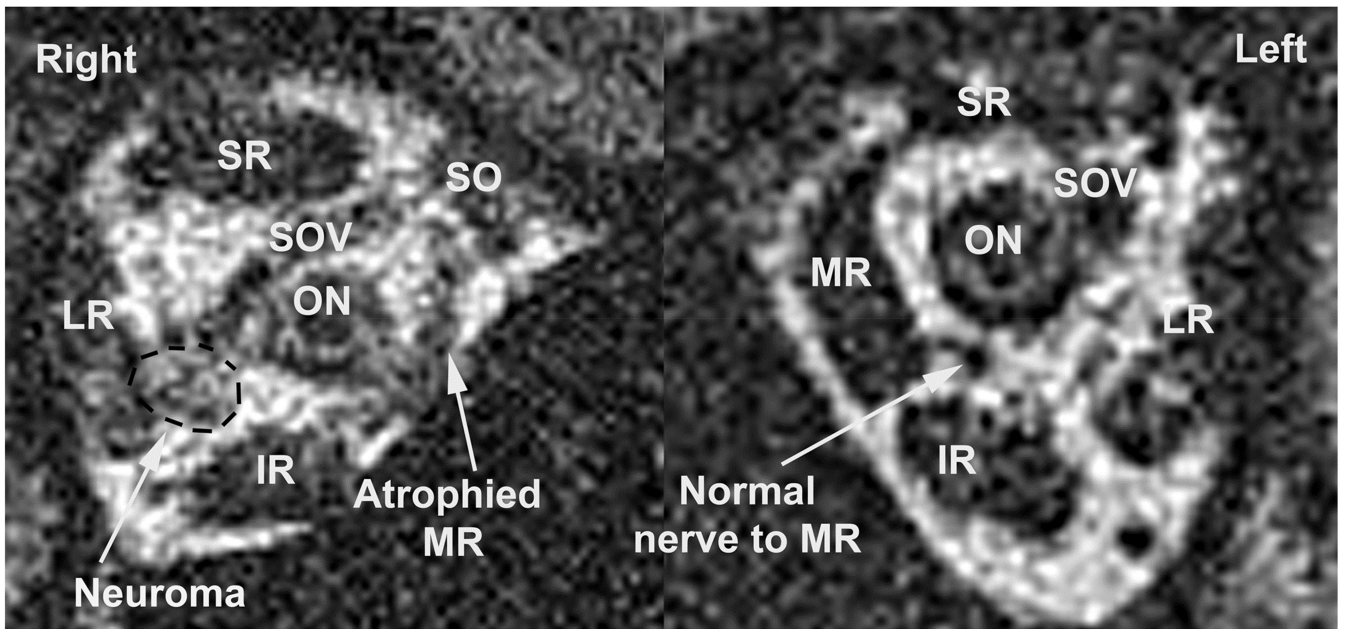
Contrast-enhanced coronal T1-weighted surface coil MRI of right orbit of case 2 demonstrating a 3.3×2.8 mm enhancing lesion in the path of the motor nerve to the medial rectus muscle compatible with schwannoma. *IR*, inferior rectus muscle; *LR*, lateral rectus muscle; *MR*, medial rectus muscle; *ON*, optic nerve; *SOV*, superior ophthalmic vein; *SR*, superior rectus muscle.
